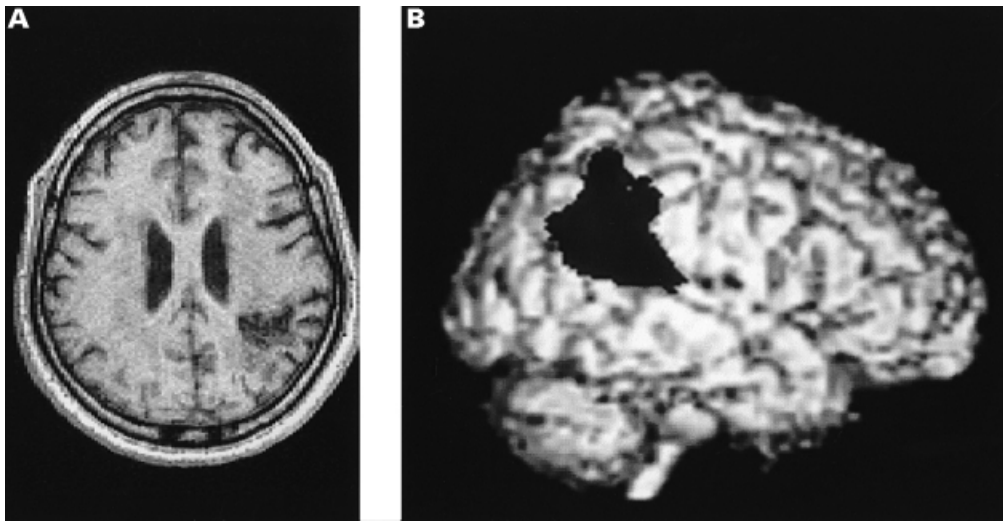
(A) Axial T₁-weighted MRI demonstrating infarction of the right parietal lobe with sparing of frontal structures in G.K. (B) Extent of the lesion on rendered reconstruction.
